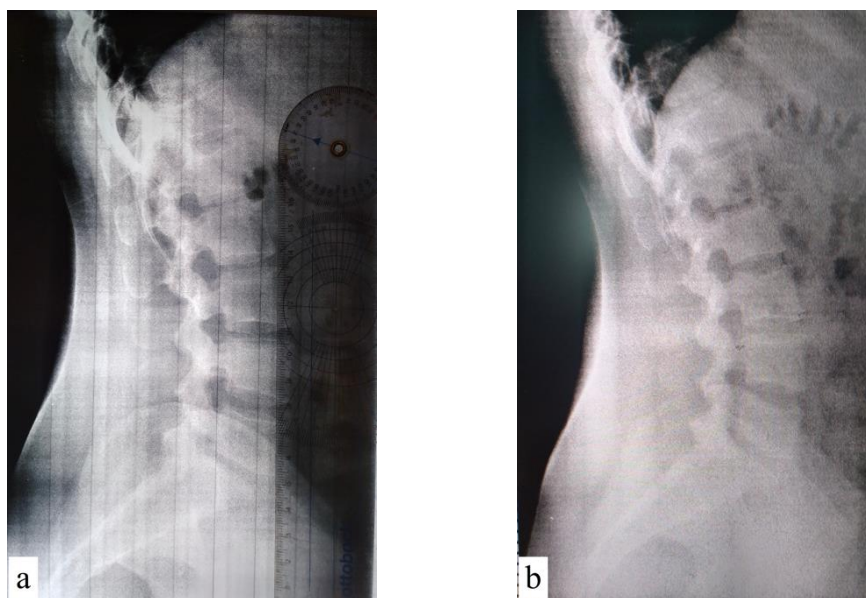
Radiographic images of the lumbar spine before and after traditional manual therapy. (a) Lateral (side) view before treatment indicating reduced vertebral angle and intervertebral narrowing, (b) Lateral view after treatment showing correction of curvature and increased intervertebral spacing.
